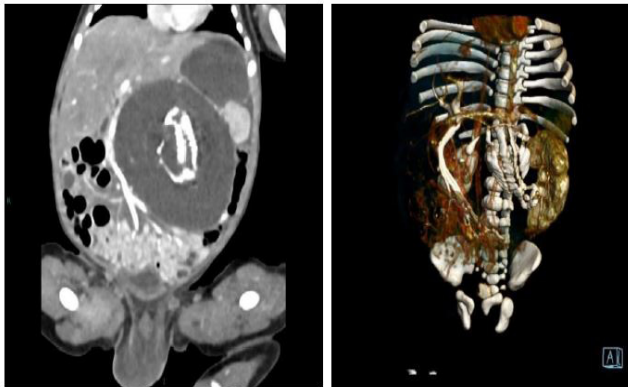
MRI images of newborn after birth. A vertebral axis can be seen in the cavum abdominis of the infant.
